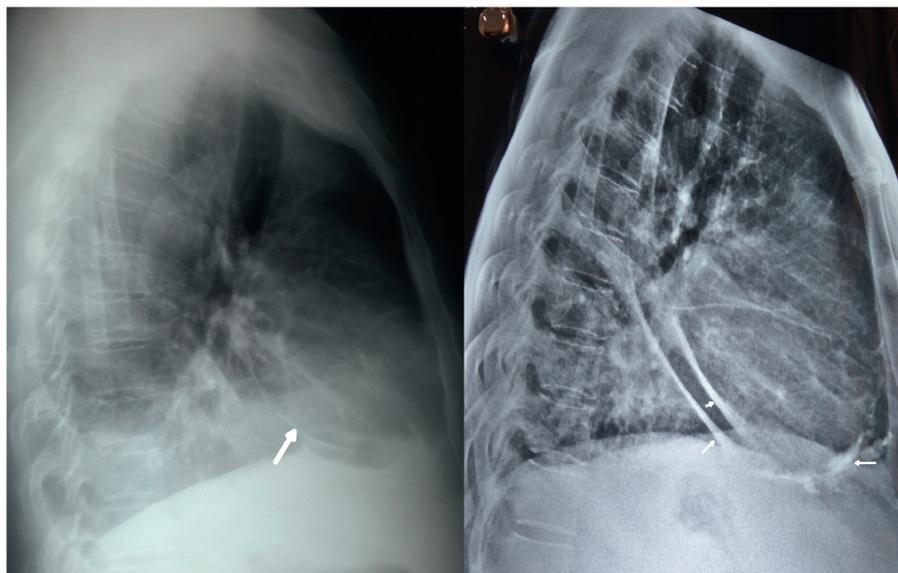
Chest radiographs showing calcification (arrows) of pericardium.
